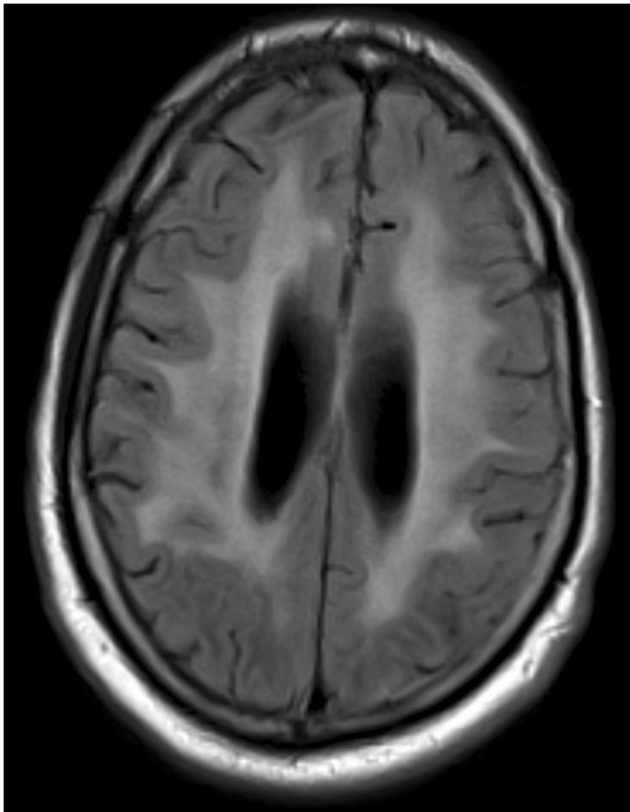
Axial T2 FLAIR-weighted magnetic resonance imaging in a 49-year-old man with a 12-year history of AIDS without opportunistic infections which demonstrates generalized atrophy, ventricular dilation, and diffuse, confluent subcortical white matter hyperintensities that spare the association fibers
